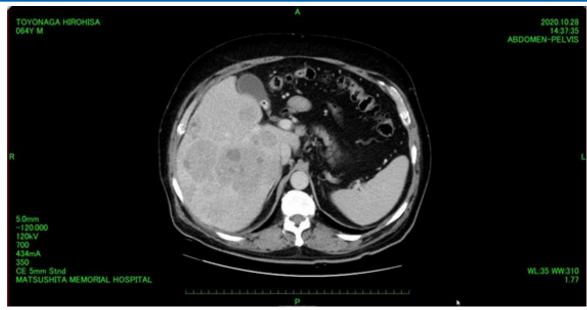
Abdominal CT Image (2020 10 28) at the Time of Diagnosis
